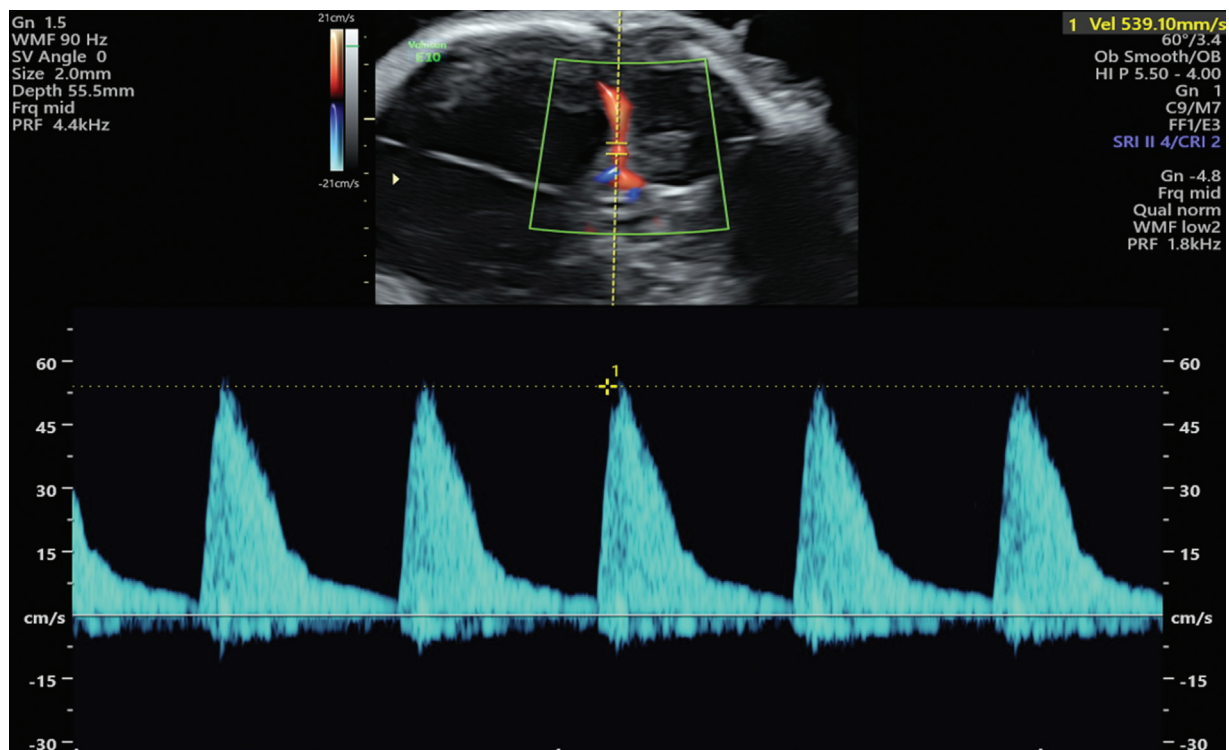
Spectral Doppler of MCA in a fetus with severe HDFN. This image demonstrates the technique for measuring the MCA PSV. For the objective of assessing fetal anemia, MCA PSV is assessed between 18 and 35 weeks of gestation. The axial image of fetal brain is insonated with color Doppler and the circle of Willis is demonstrated. A pulsed Doppler gate of width 2 mm is placed at the proximal 2 cm of the MCA from its origin. The chief prerequisites to be observed are maternal and fetal quiescence, avoiding undue pressure with transducer and maintaining an insonation angle of 0 degree ideally (always < 20 degree). Three measurements under ideal condition are documented. HDFN, hemolytic disease of newborn; MCA, middle cerebral artery; PSV, peak systolic velocity.
